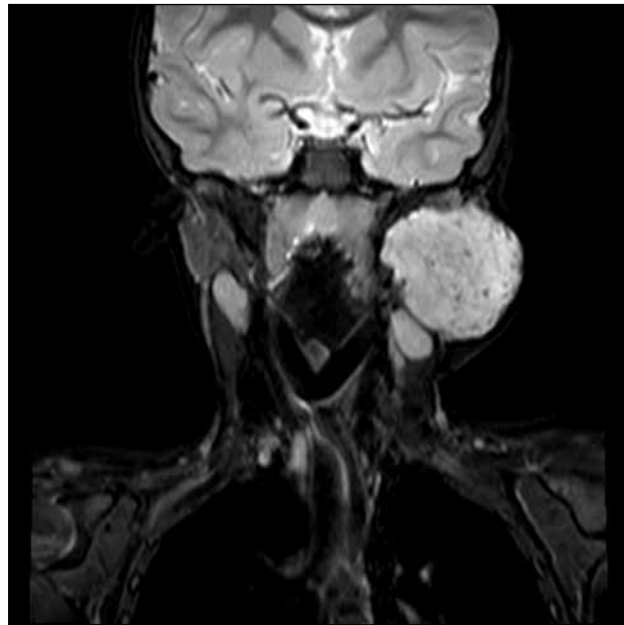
Coronal T2-weighted image demonstrating large left parotid VM.
